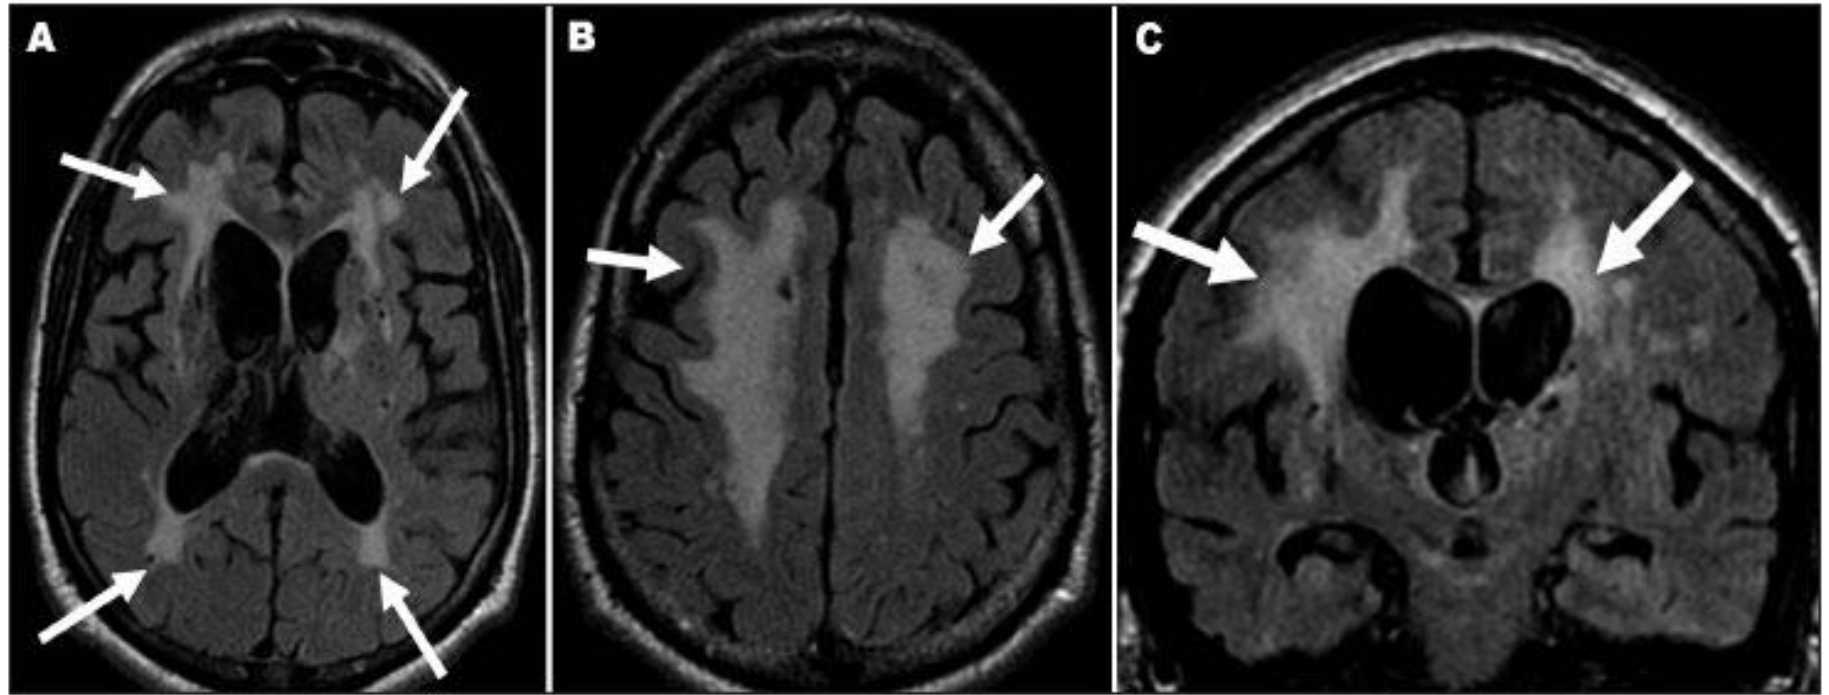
Flair MRI of a patient with higher score in Fazekas scale; white matter lesions (WML) are shown by arrows: [A] periventricular WML affecting anterior and posterior horns, bilaterally (axial section); diffuse ([B] axial section) and deep WML ([C] coronal section). Courtesy of Hospital Pró-Cardiaco, RJ.
